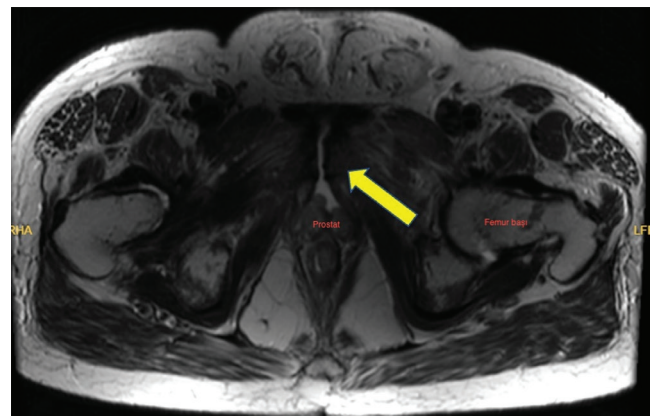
Pelvic MRI. Axial T2 image demonstrates the prostatosymphyseal fistula (arrow)
